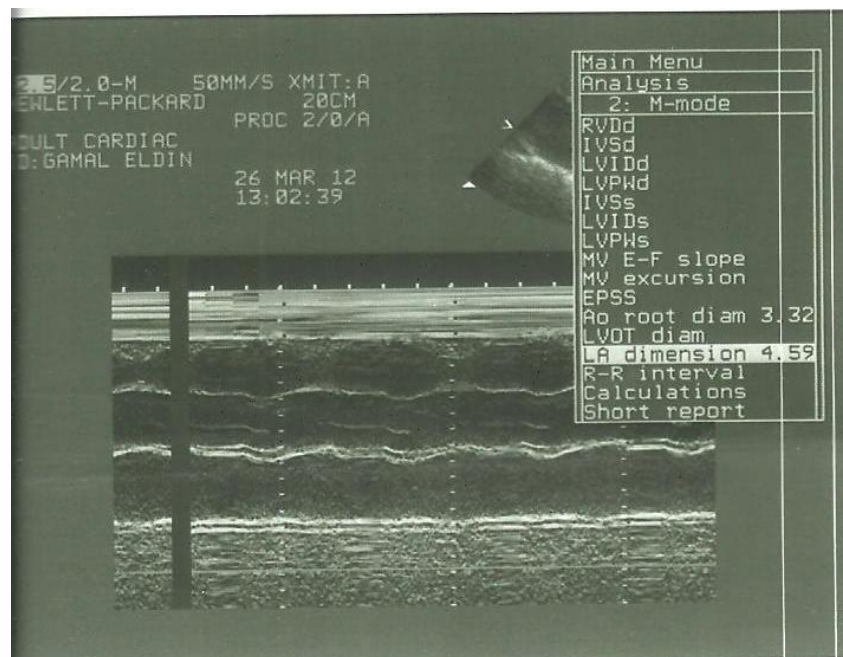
resting echocardiogram showing left atrial diameter =4.59 cm
